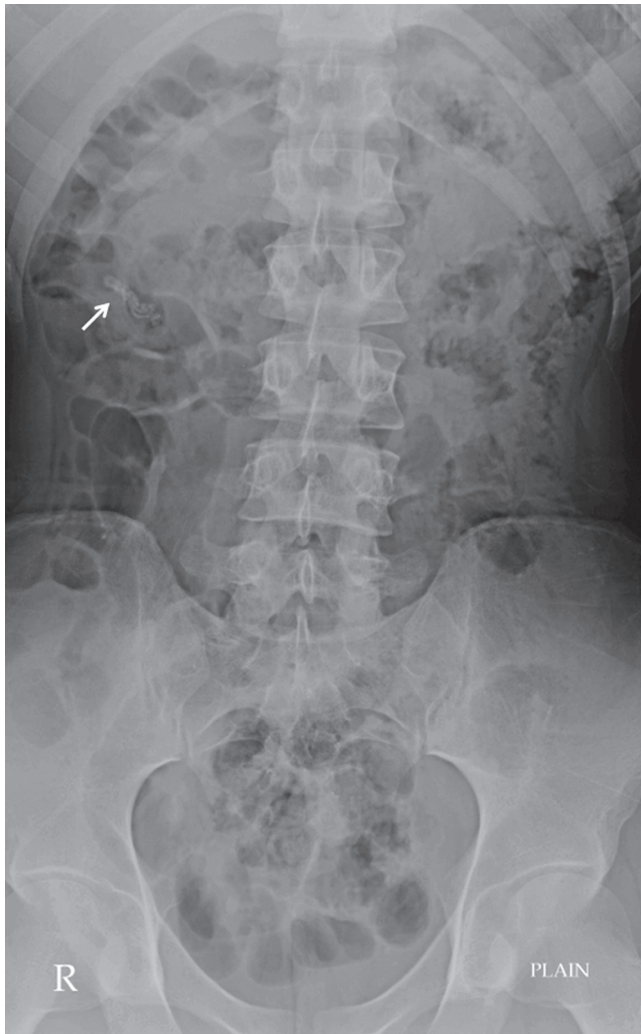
Plain supine abdominal film in a patient with renal colic. The multiple stones in the right renal area (*white arrow*) are difficult to visualize owing to significant amount of overlying bowel gas. Neither renal outline could be seen. Situations such as this are common and difficult to overcome. Additional imaging (usually with CT) is required to confirm the presence of stones
